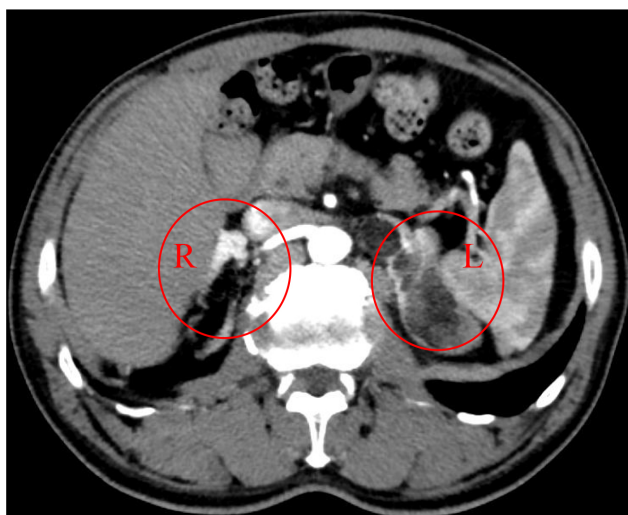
Renal tumor evaluation and computed tomography angiography (CTA). Thickening of the right adrenal gland and multiple lesions in the left adrenal gland (circles) were observed.
